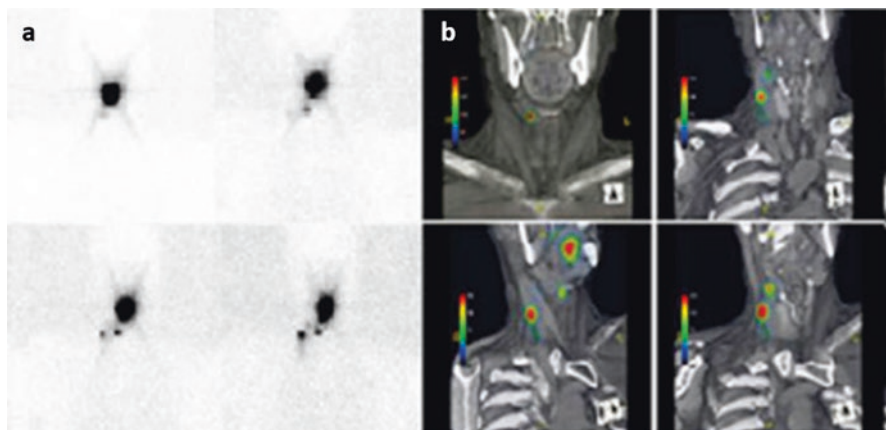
Comparisons between conventional planar lymphoscintigraphy (PI, a) and Lymphoseek® SPECT/CT (b) of a patient with floor of mouth carcinoma in relationship to SLN locations. The exquisite anatomical information provided by SPECT/CT can enhance the surgeon's view of the operating field, as well as help develop new intraoperative identification methods. (Adapted with permission from [54])
